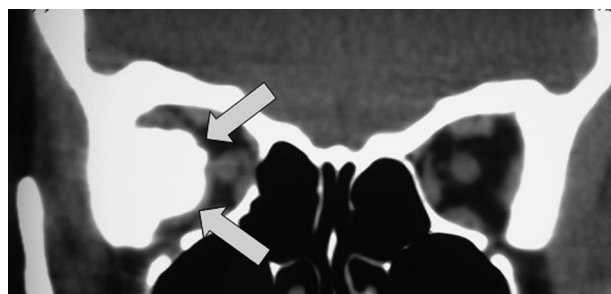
Coronal T₁ CT shows a well-defined, hyperdense, lobulated lesion emerging from the lateral orbital wall (arrows).
